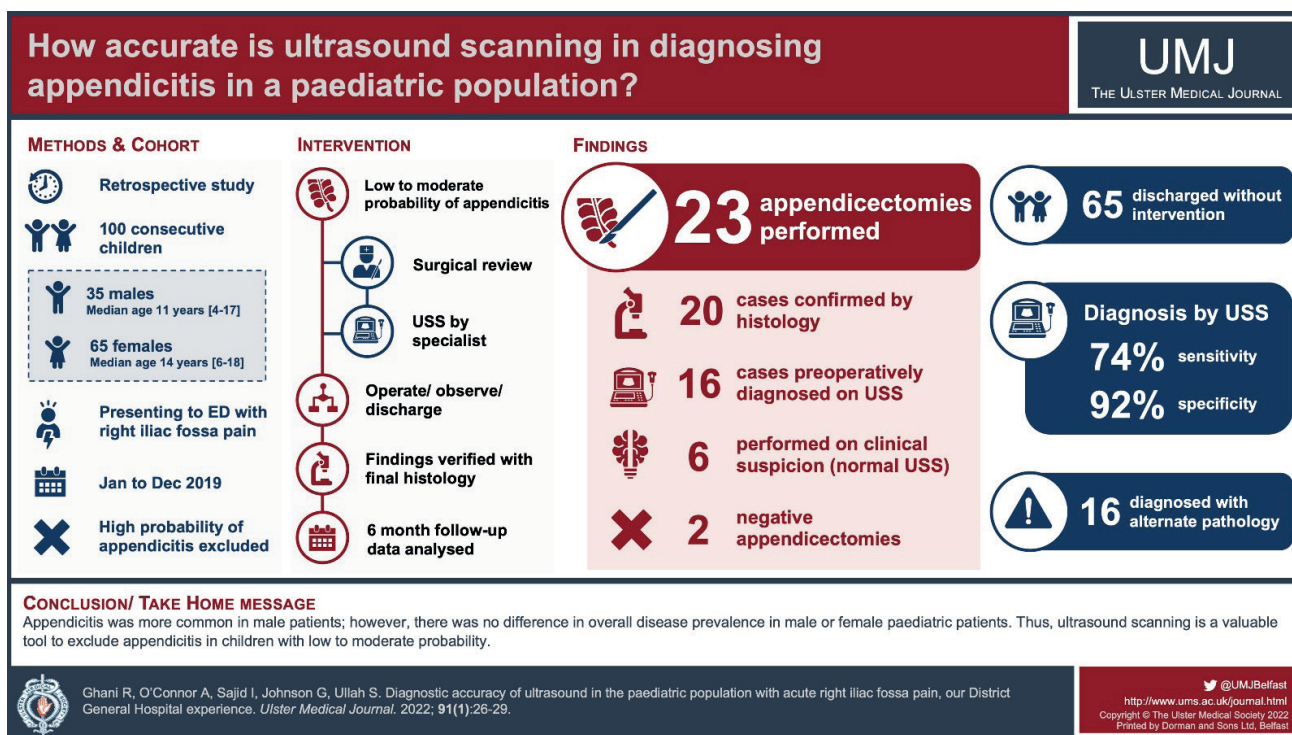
Paired (a) written abstract and (b) visual abstract of a clinical paper previously published in the Ulster Medical Journal entitled “Diagnostic accuracy of ultrasound in the paediatric population with acute right iliac fossa pain, our District General Hospital experience”.³¹
